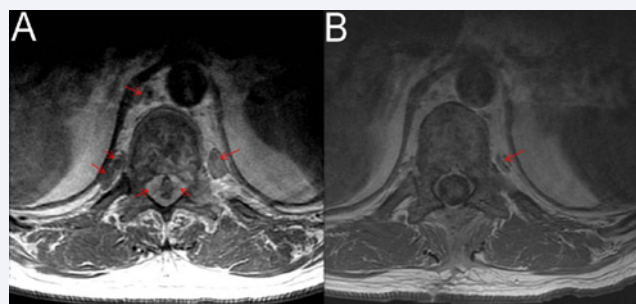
(A) - [Pretherapy MRI with paraspinal and epidural lesions indicated by the red arrows] (B) - [Post Imatinib treatment showing essentially complete resolution of the lesions].
